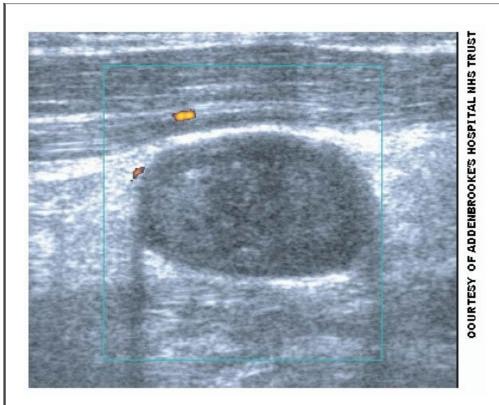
Ultrasound of a malignant lymph node. A sign of malignant infiltration is loss of the fatty hilum. Duplex mode (within the green box) shows loss of the normal hilar vascularity.
